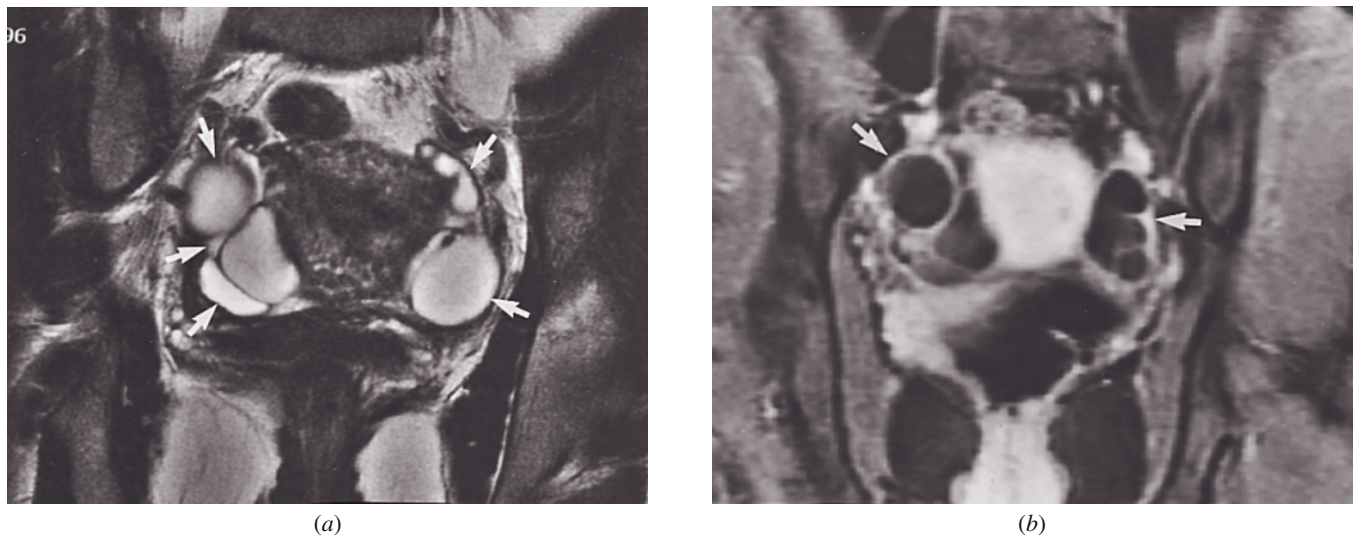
Pelvic inflammatory disease. Coronal 512-resolution T2-weighted ETSE (*a*) and gadolinium-enhanced T1-weighted fat-suppressed gradient-echo (*b*) images in a patient with acute pelvic pain and fever. Bilateral complex cystic masses are not ovarian cysts but the inflamed, dilated fallopian tubes folded upon themselves (arrows, *a*), flanking the uterus. After contrast the tube walls enhance and further demonstrate that the masses are not adjacent discrete cysts, but rather continuous structures (arrows, *b*).
